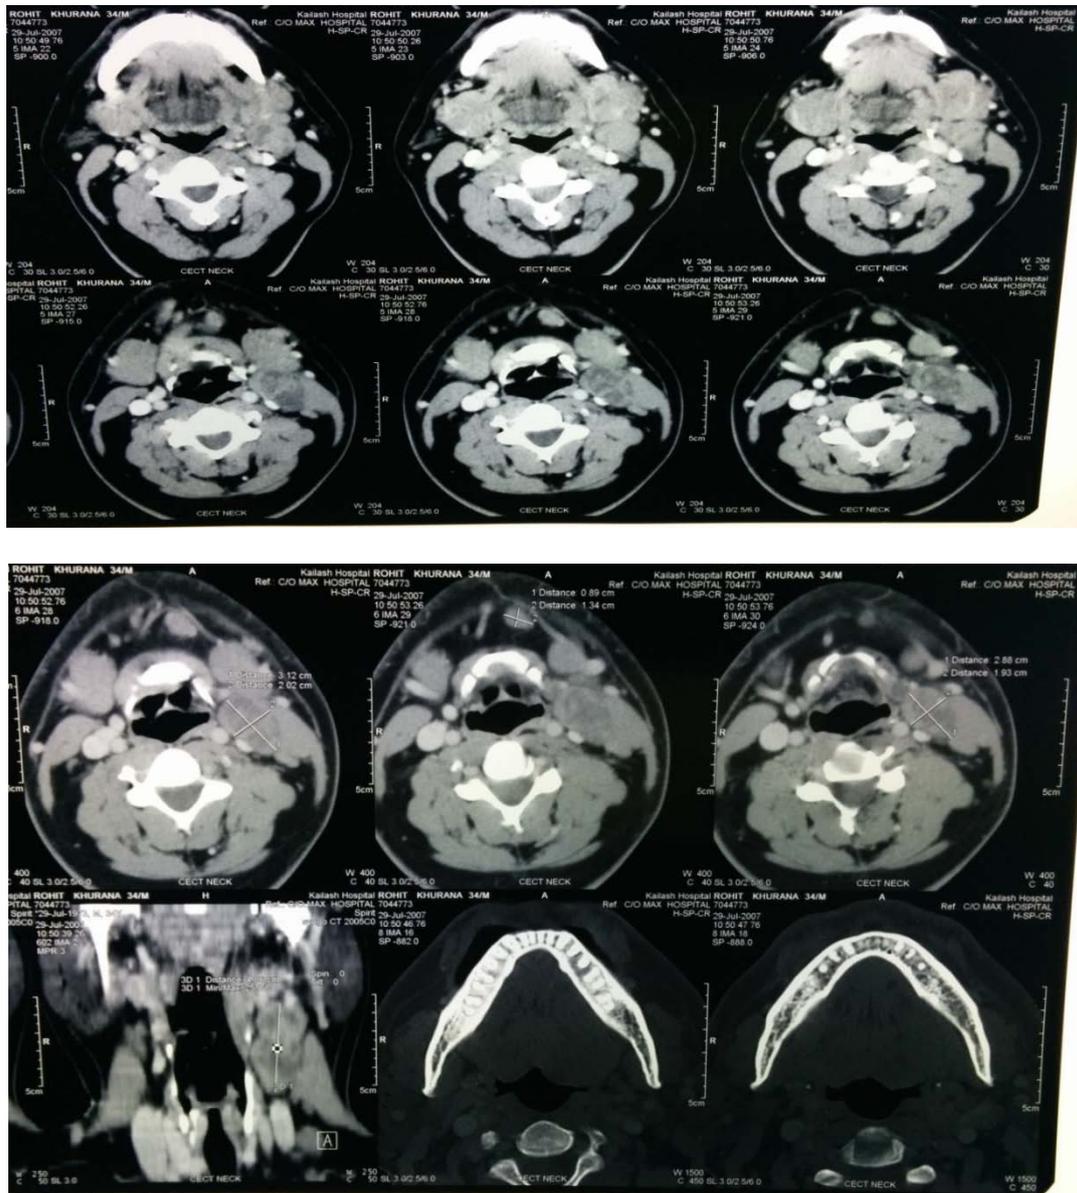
CT Report of Oropharynx: At the Time of Admission on 29th May 2007
